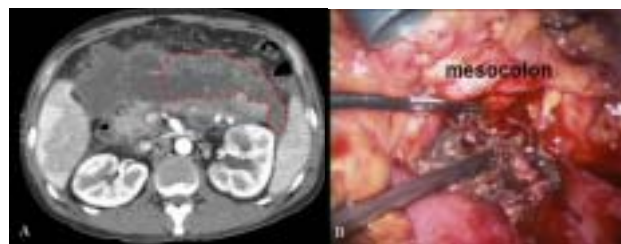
A 30 year old man, with severe necrotizing pancreatitis. (A) CT shows severe necrosis around pancreas. Demarcated area was approached and debrided using the transmesocolic method (B), the other was approached using a transgastric or extrapancreatic approach
